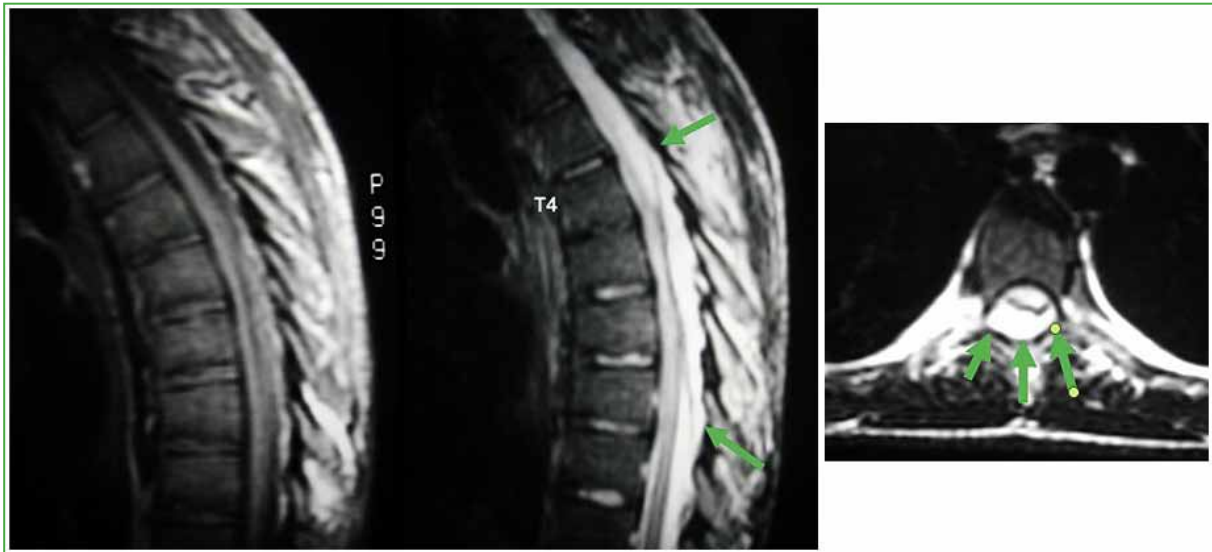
Case 10. MRI, T1- and T2-weighted sagittal sections, and T2-weighted axial section. Defined as T4-T8, P, C2 (Region: T4-T8, Location: posterior; Involvement: compresses the content). In cases of posterior pyogenic spinal epidural abscess, there may not have association; therefore, it is association and perivertebral negative.
